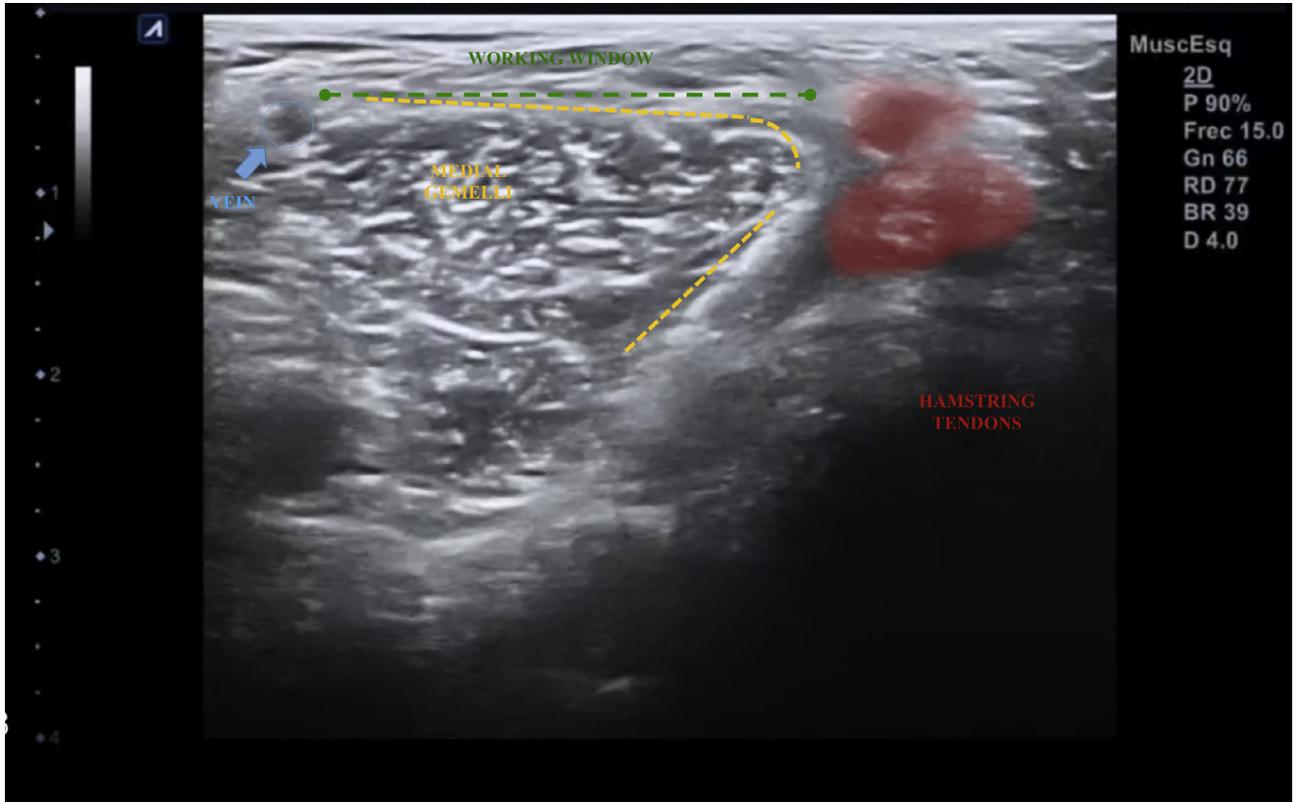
Transverse ultrasound views of the sural vein, gemelli, and hamstrings.
